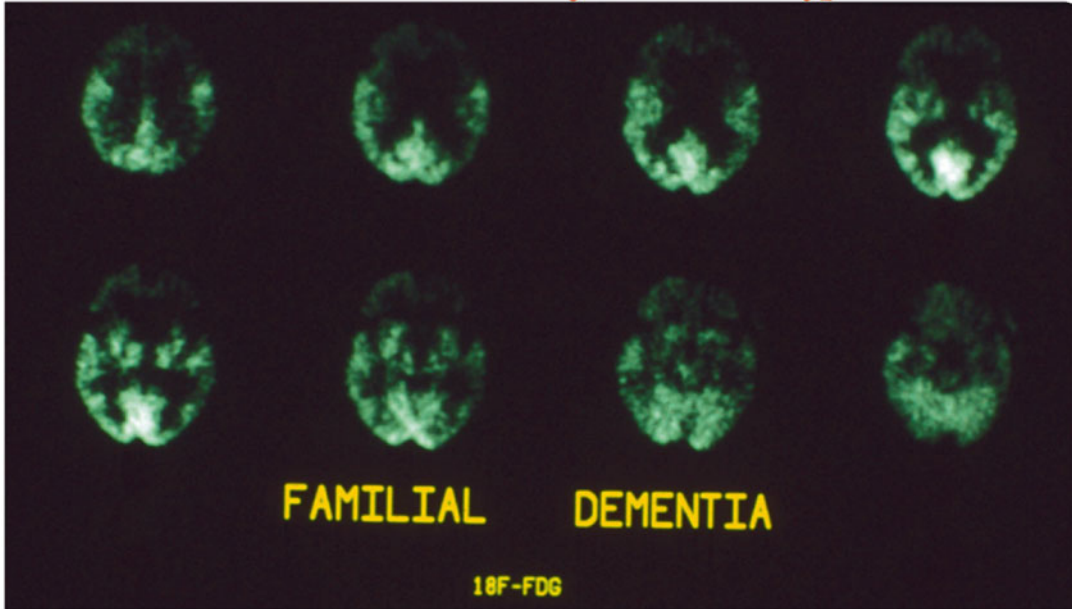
Familial fronto-temporal dementia (FTD): Presumed FTD in a 82-year-old patient with progressively severe dementia presenting in an identical form experienced by an older brother who also had a FDG
